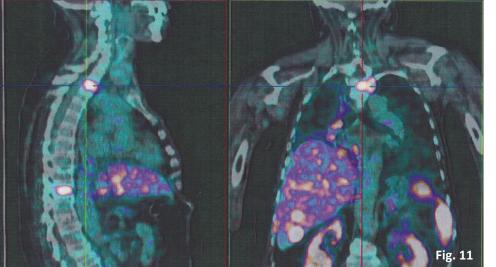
68-Ga DOTATATE PET/CT
